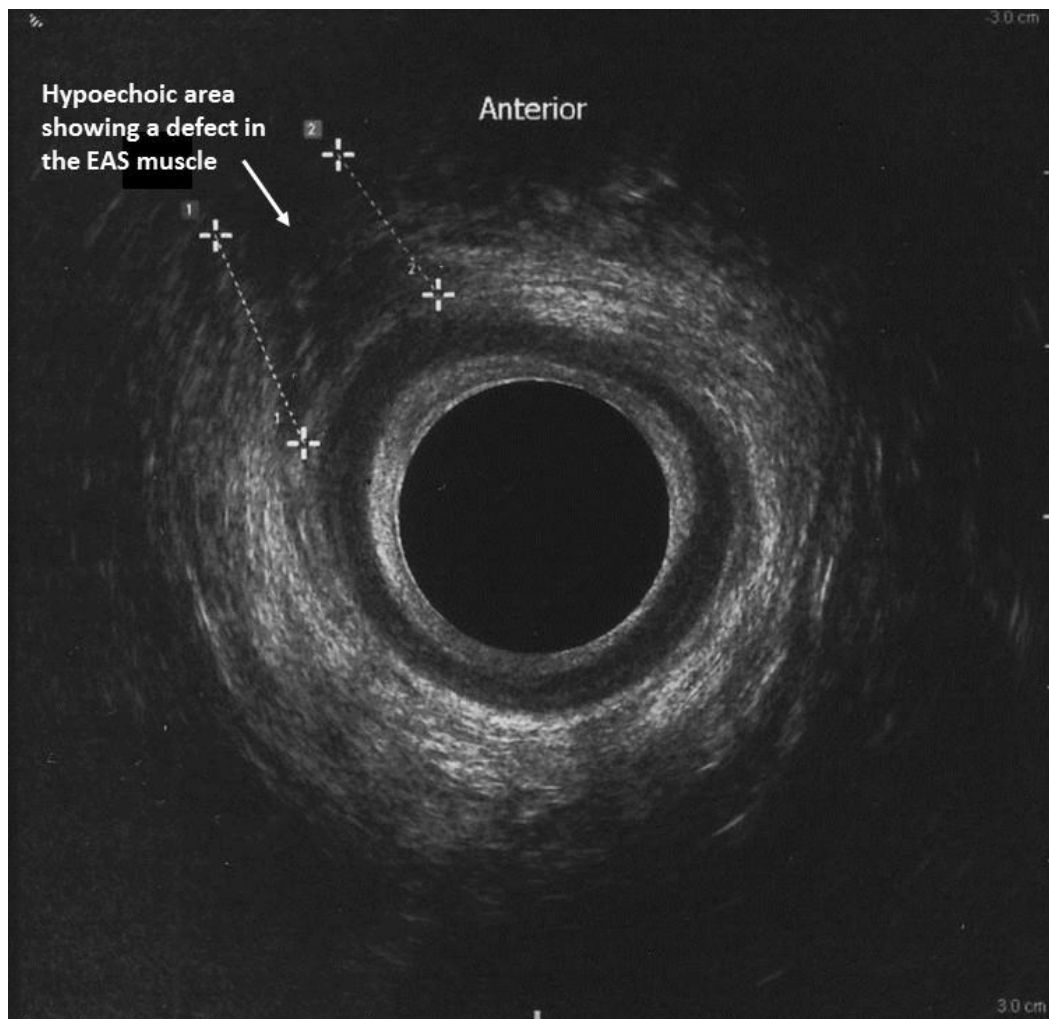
Ultrasound image showing a defect in the external anal sphincter
